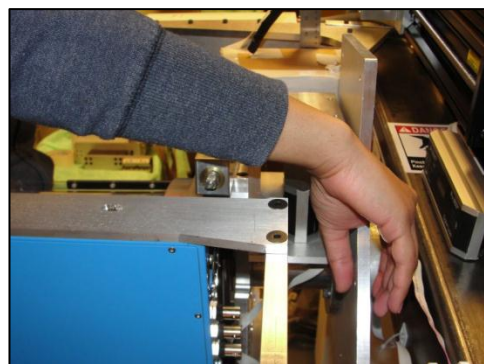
Photograph of x-ray detector & patient arm collision
